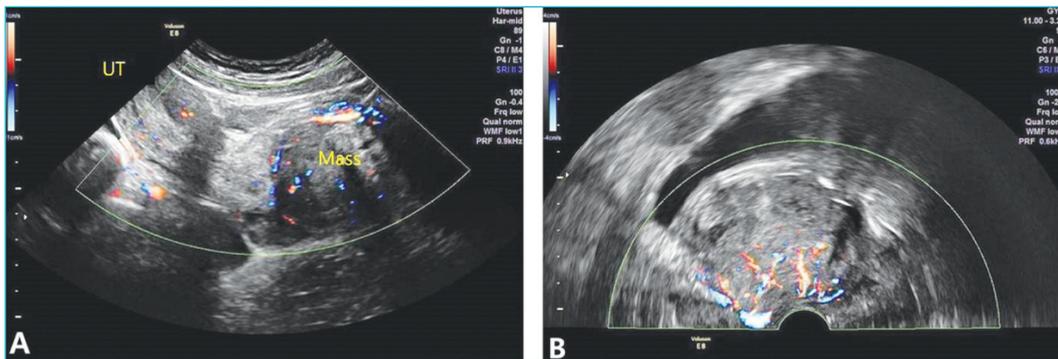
A) Trans-abdominal ultrasound image shows a well circumscribed of between cervix and anterior vaginal wall; B) Trans-rectal ultrasound image shows lower genital tract mass with hetero-echogenicity and focal vascularity on color Doppler. UT: Uterus.
